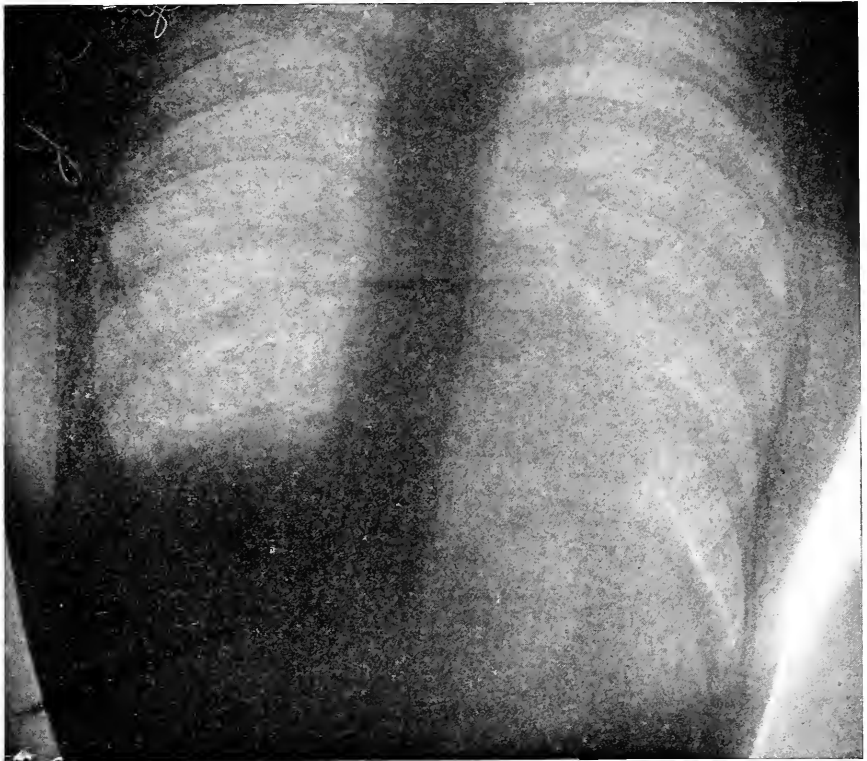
Obliteration of complementary pleural space and adhesion of diaphragm to chest wall on right side, following a pleural effusion. (Roentgenogram by Dr. H. K. Pancoast.)
